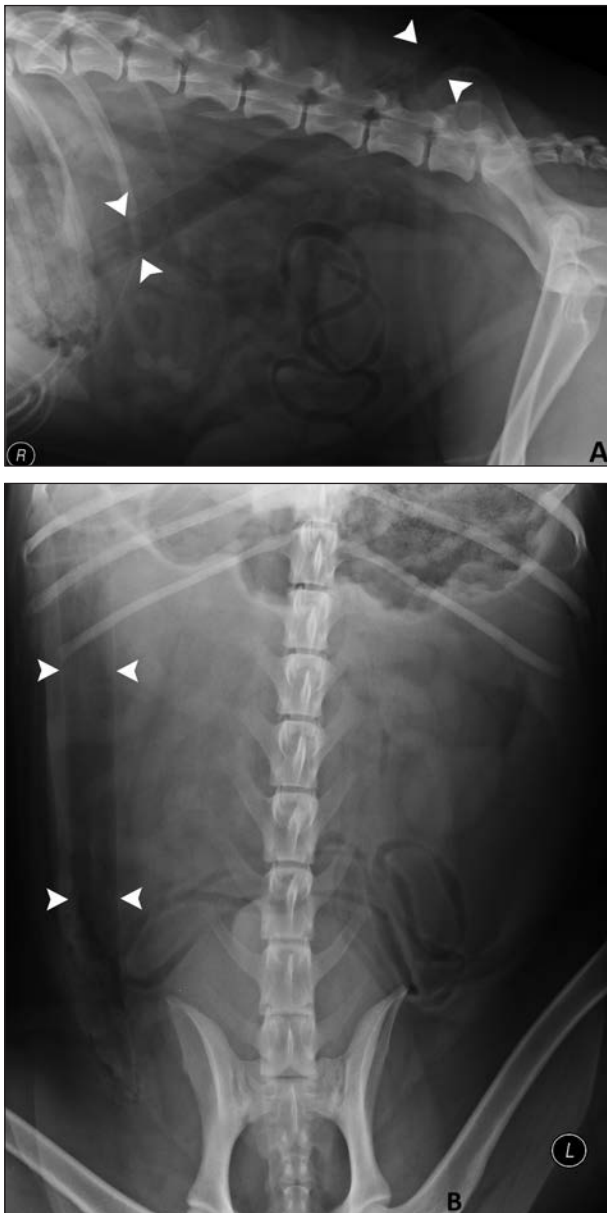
Same radiographic images as in Figure 1. A cylindrical radiolucent structure is evident in the right side of the abdomen extending into the subcutaneous tissues lateral to the right ilium (arrowheads). L = Left. R = Right.
